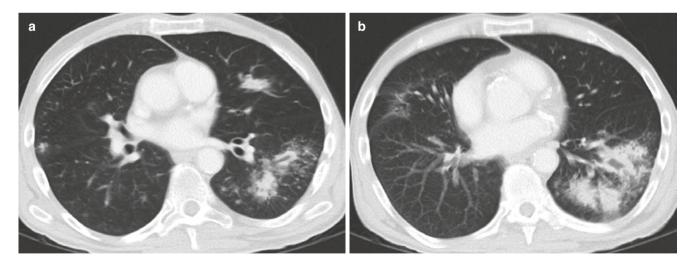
Evolving pneumatoceles from aspiration pneumonia. (a, b) Axial CT images show consolidations in the left lower lobe and upper lobe. (c, d) Follow-up CT images after 6 months show cyst formation (arrows) at the site of prior pneumonia
